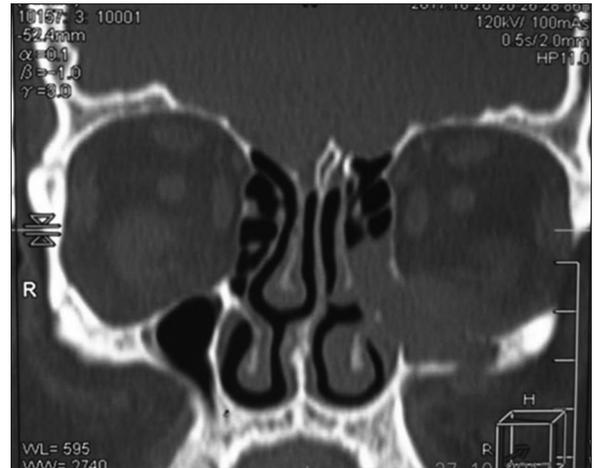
Computed tomography-paranasal sinus showing heterogeneous mass with wall erosions, destruction, and sclerosis
